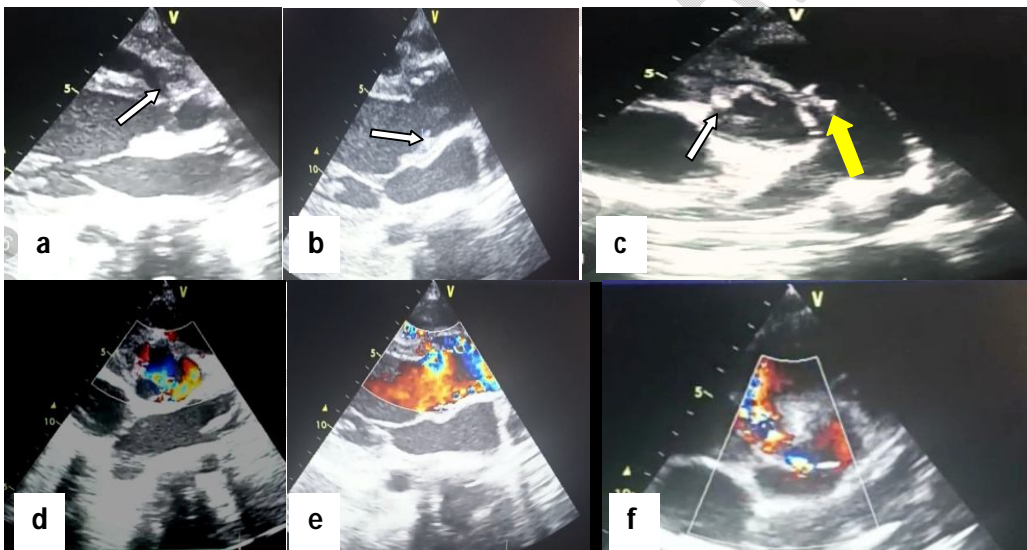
Transthoracic echography: a)Left parasternal long axis with Breach (white arrow) between aorta and right ventricular with irregular shoreline related a large fistula; b)Aortomitral curtain (White arrow); c): Mutilated pulmonary valve with vegetation (large white arrow); Large abscess in pulmonary outflow in contact with breach (small white arrow); d) and e): Severe aortic regurgitation; f):Flow passage between the aorta and pulmonary tract.
